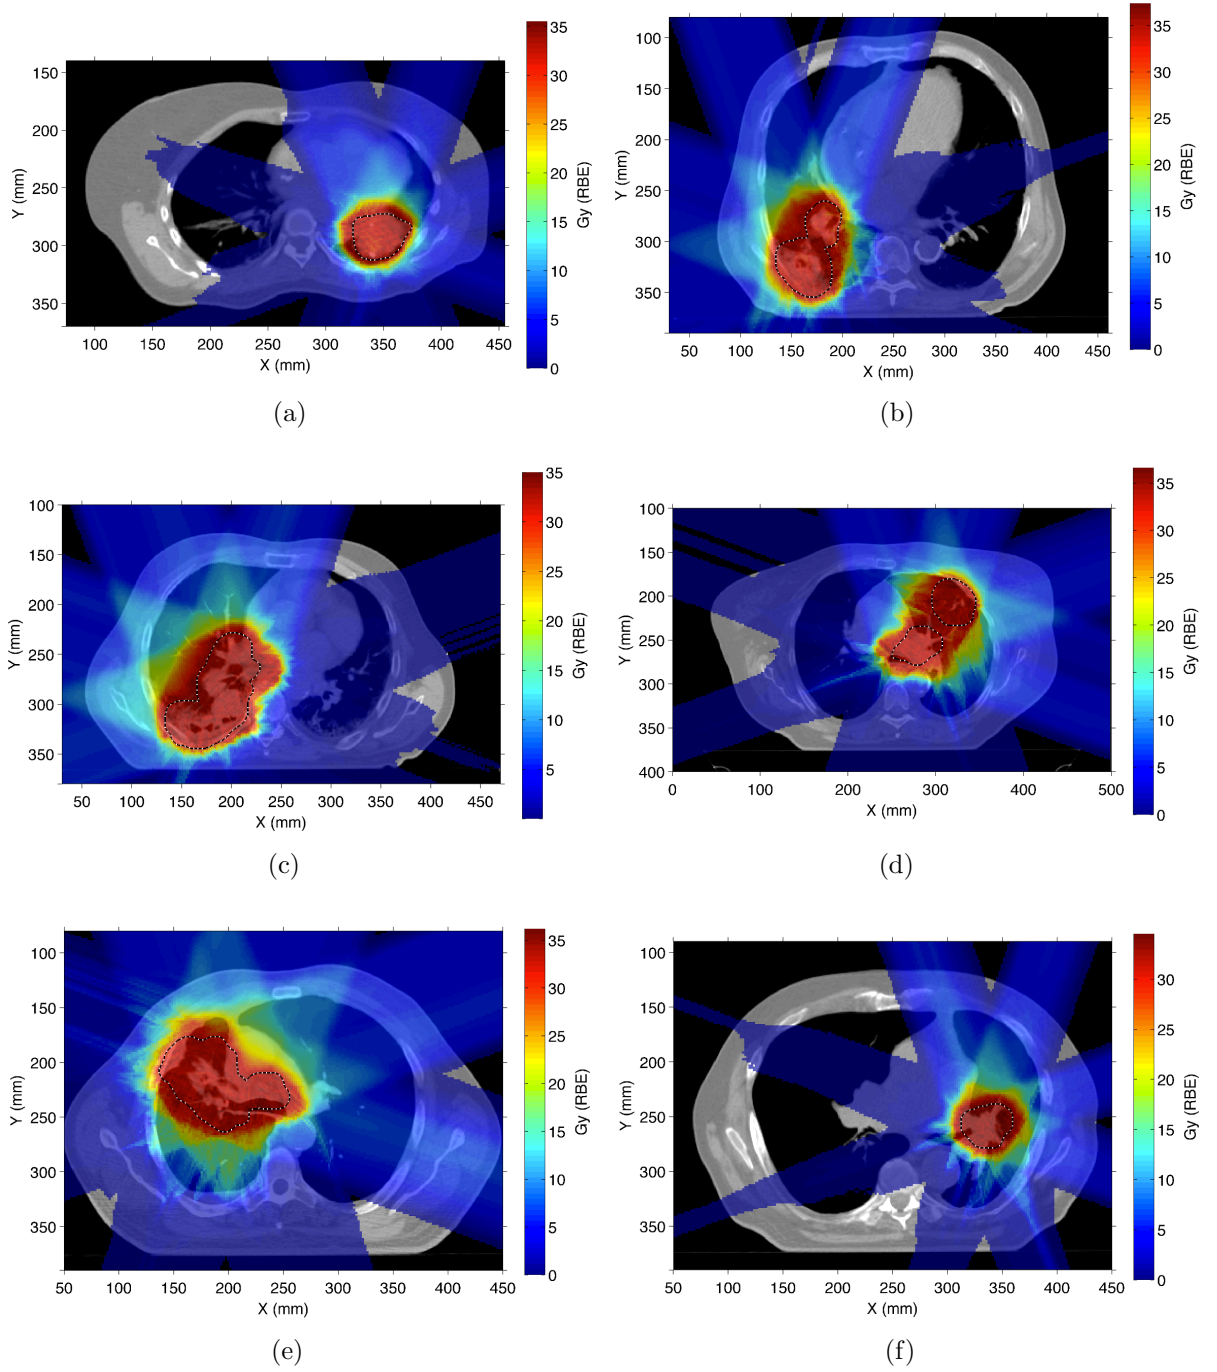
Axial view of RBE-weighted dose overlaying CT shown for Lung Patients #1 - #6, indicated by (a) - (f), respectively, for perfect tracking for a reference case with $\tau = 4$ s and $\phi = 0$ degrees. This figure gives a view of our treatment plans and shows the variation in patient anatomy and tumor size for our 6 lung patients.
